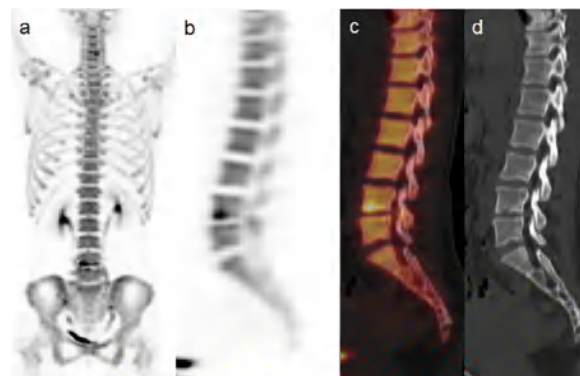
$^{18}\text{F}$ -NaF positron emission tomography image of a 38-year-old patient who was diagnosed with ankylosing spondylitis according to the Assessment of SpondyloArthritis International Society criteria and tested positive for serological human leucocyte antigen-B27. However, significant  $^{18}\text{F}$ -NaF uptake was observed at the lower end plate of L4 (maximum standardized uptake value [SUVmax]=8.53) and upper end plate L5 (SUVmax=6.92; a), which is suggestive of degenerative changes in the L-spines. Diagnosis of degenerative change in the lower back was made; this diagnosis was supported by the presence of Schmorl's nodes, which were found on the sagittal plane images of both positron emission tomography and nonenhanced computed tomography (b–d). This case was considered to be false positive.
